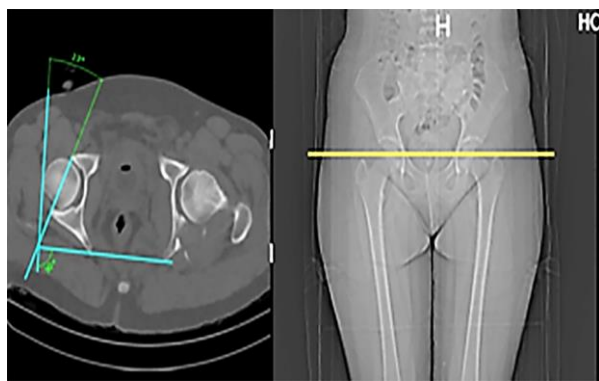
Calculation of acetabular version on computed tomography (CT) scan images; representative images demonstrating the method used
